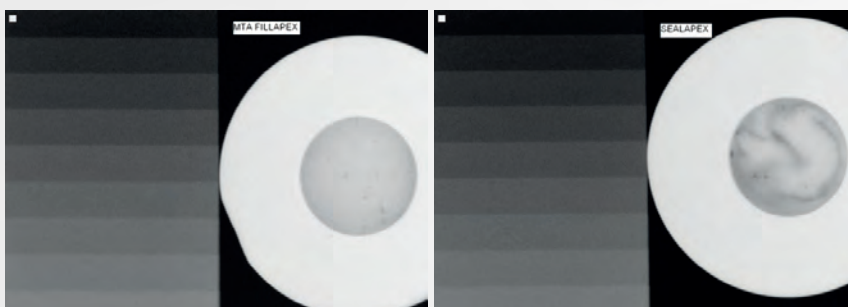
Figure with X-ray images of MTA-Fillapex and Sealapex compared to the aluminum scale
